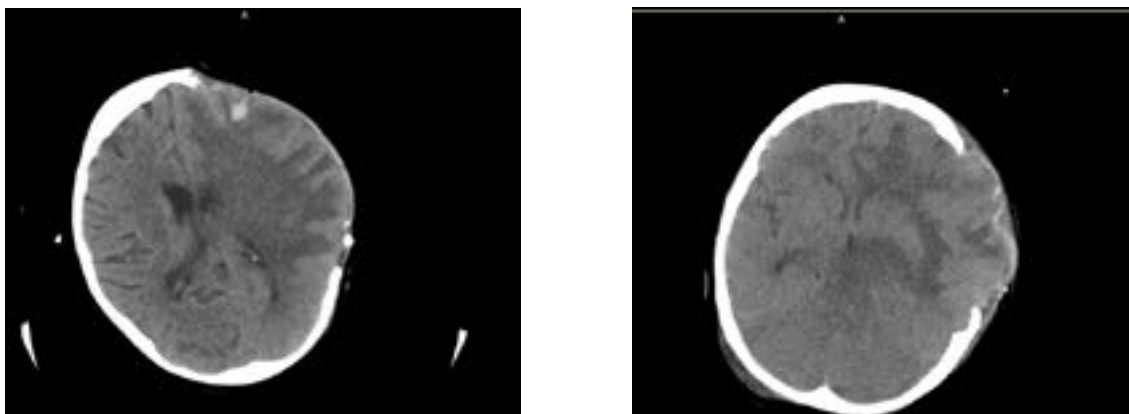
Brain CT without contrast fronto-temporo-parietal cut
